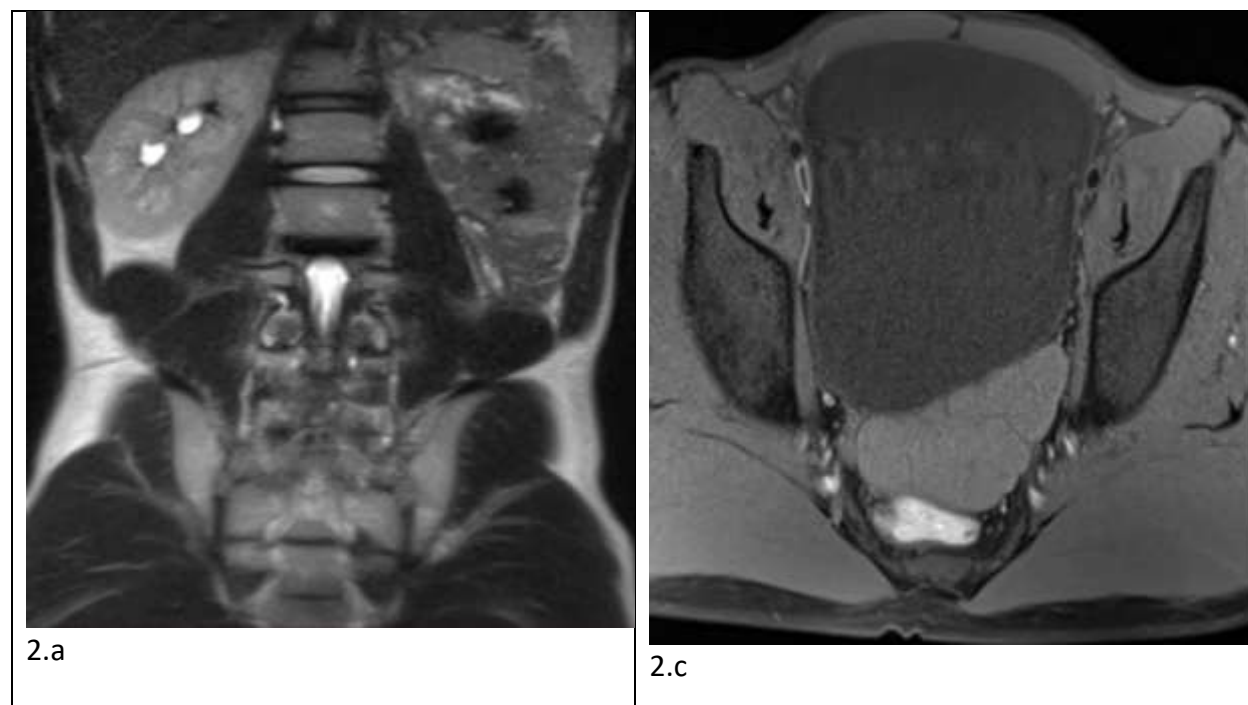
(a,b) Coronal and axial CT scans show an empty left renal fossa, indicating the absence of the left kidney; and (c,d) coronal and axial CT images revealing non-enhancing lobulated left retro-vesical cystic structure diagnostic of seminal vesicle cyst
